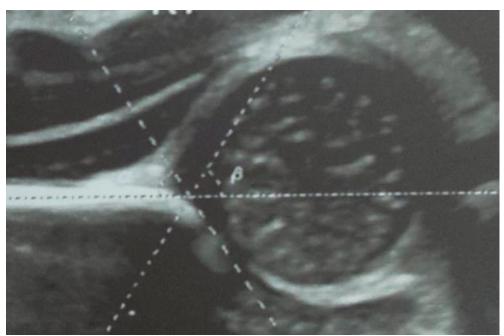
An ultrasound image of current study showing a 14 day-old-boy with Graf Type- IIa+ with alpha angle 50 & beta angle 66 (Physiological Immature Hip).
